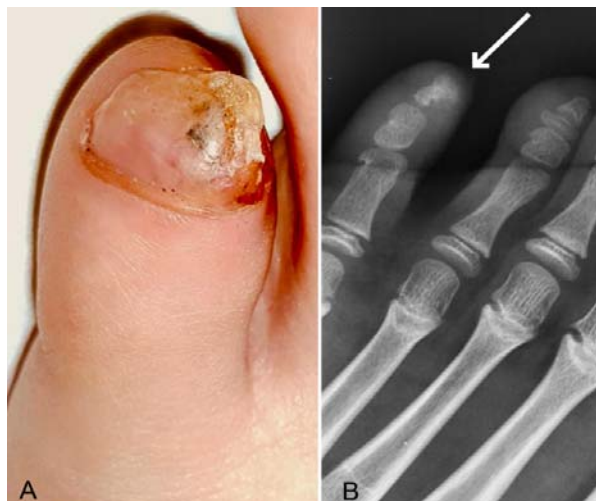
Dupuytren's subungual exostosis; (a) mass under the nail of fifth toe causing onycholysis, and (b) radiograph showing dorsomedial exostosis (arrow).
